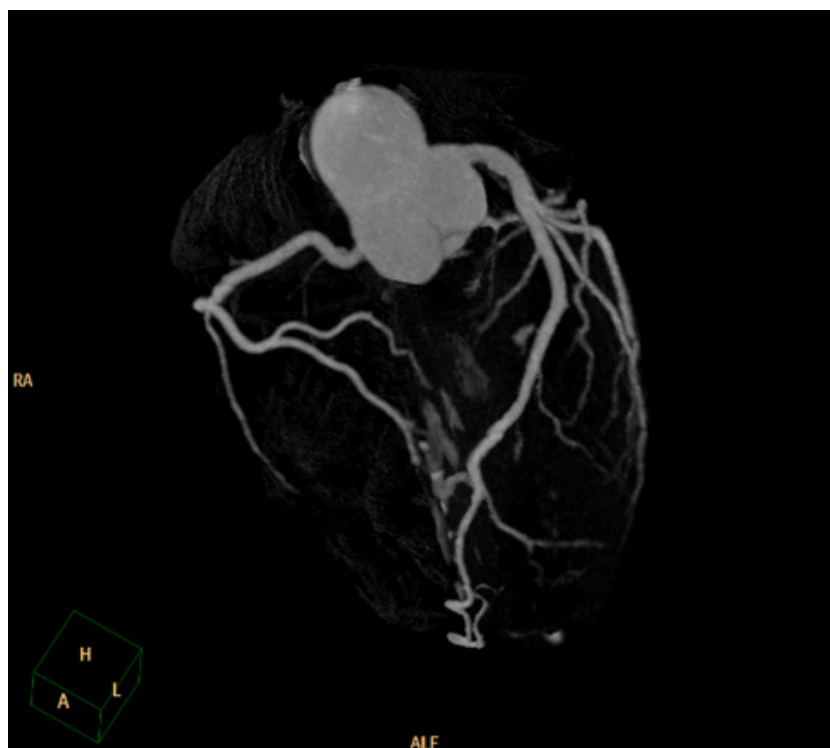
Case 6 - Coronary angio-CT within normality.
